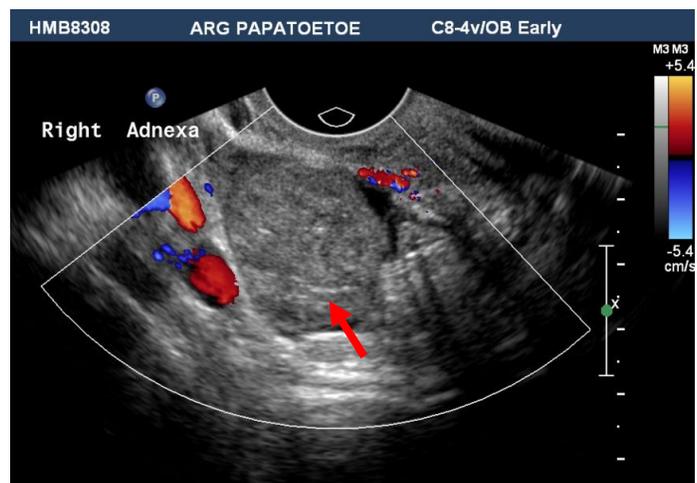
Transvaginal ultrasound with colour Doppler identifies an unruptured right tubal ectopic pregnancy (arrow). Clinical history of pain with slowly rising serum b-HCG levels.
